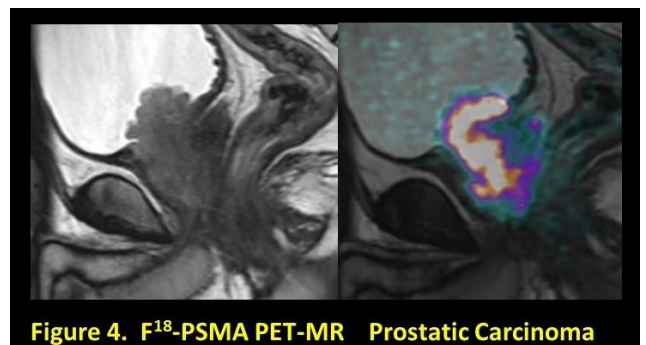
F¹⁸-PSMA PET-MR Prostatic Carcinoma
